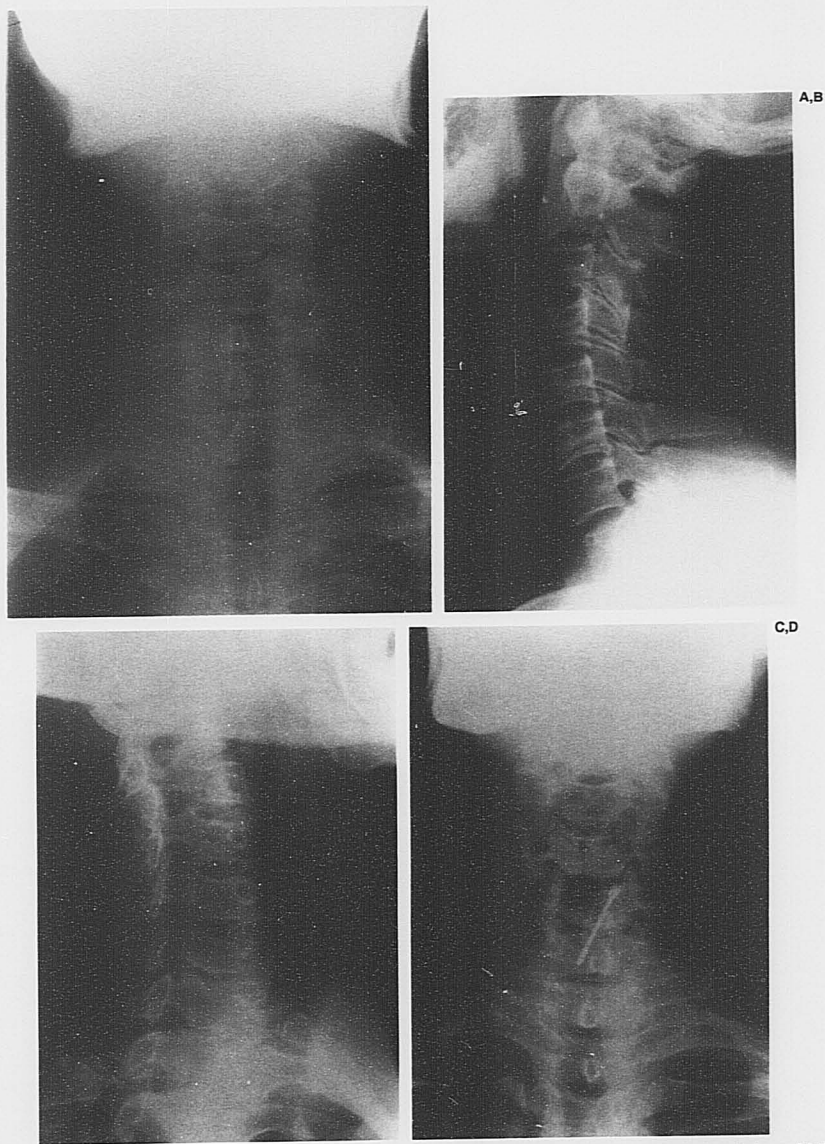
Anteroposterior (A), lateral (B), and oblique roentgenograms (C) before surgery of a 51-year-old man who had cervical spondylotic neuropathy demonstrating posterior and posterolateral osteophytes at C6-7. Anteroposterior (D) and lateral roentgenograms (E, p. 128) taken 6 months after surgery demonstrating one intraosseous Herbert screw fixation of the graft construct and solid union of the graft construct.
